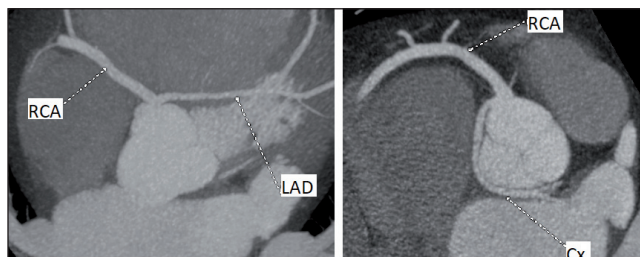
Coronary computed tomography: Axial images of an ectopic connection of the left coronary artery in the anterolateral sinus, close to the birth of the right coronary artery. Cx – circumflex artery; LAD – left descending artery; RCA – right coronary artery.
